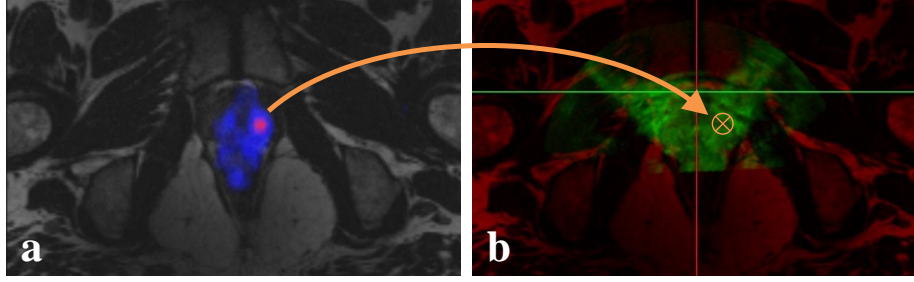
Transfer of biopsy targets from PET to 3D TRUS via MRI for patient case 1. a) PET/MRI with targets in pink, b) 3D TRUS (green) registered to MRI image (red) after landmark-based registration.
